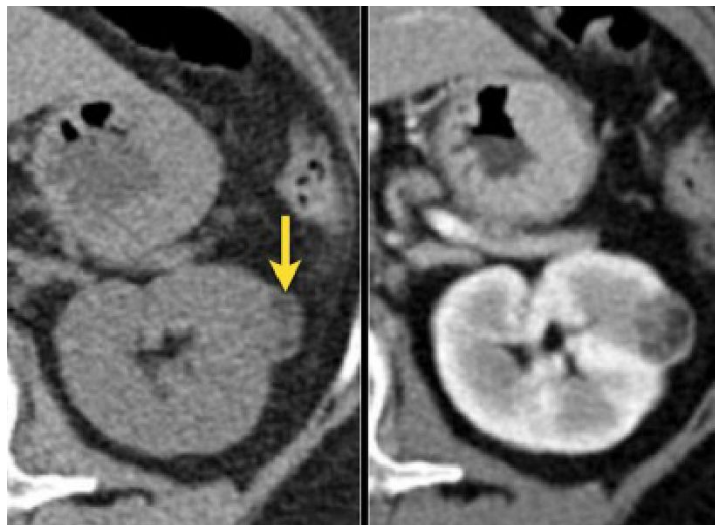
Contrast enhanced CT showing angiomyolipoma with areas of fat density seen arising from the left renal cortex.
